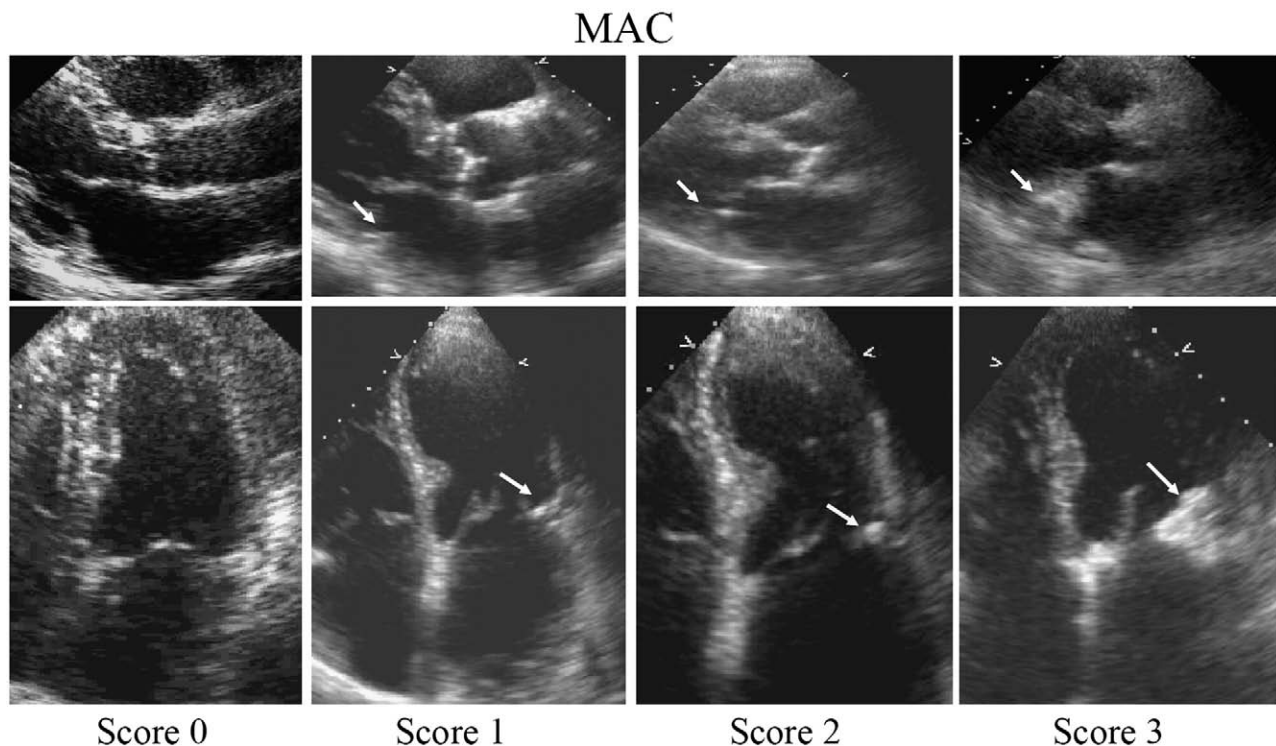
Quantification of MAC transthoracic parasternal long axis view (top) — transthoracic apical four-chamber view (bottom); score 0 — normal mitral annulus, score 1 — mild calcification of the mitral annulus, score 2 — moderate calcification of the mitral annulus, score 3 — severe calcification of the mitral annulus.
